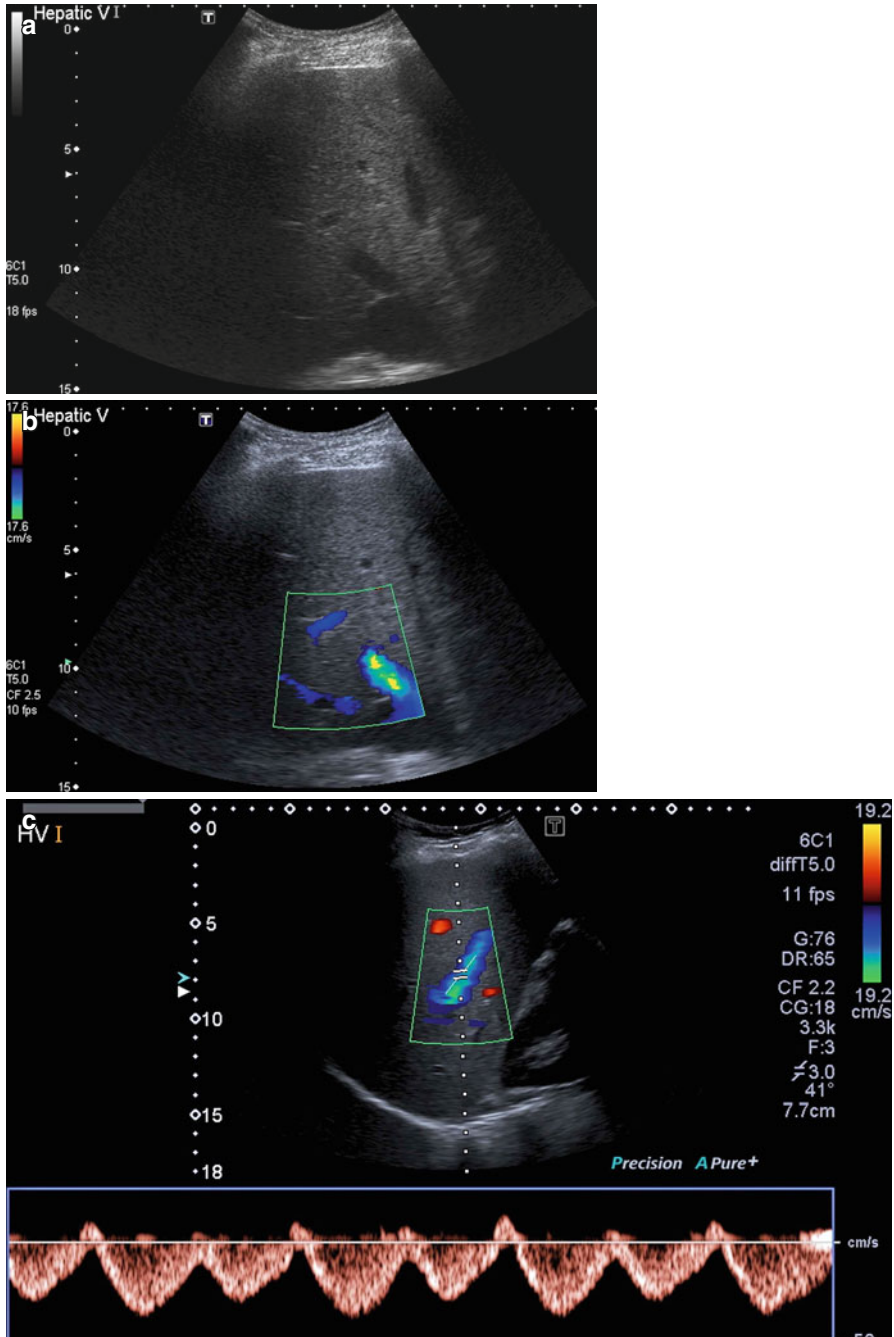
(a–c) Images of the hepatic veins. (a) Uses M-mode to give an anatomical overview. (b) Is a Doppler image, with blue colours indicating flow away from the probe. (c) Shows the phasic pulse wave Doppler signal often shown by the hepatic veins
